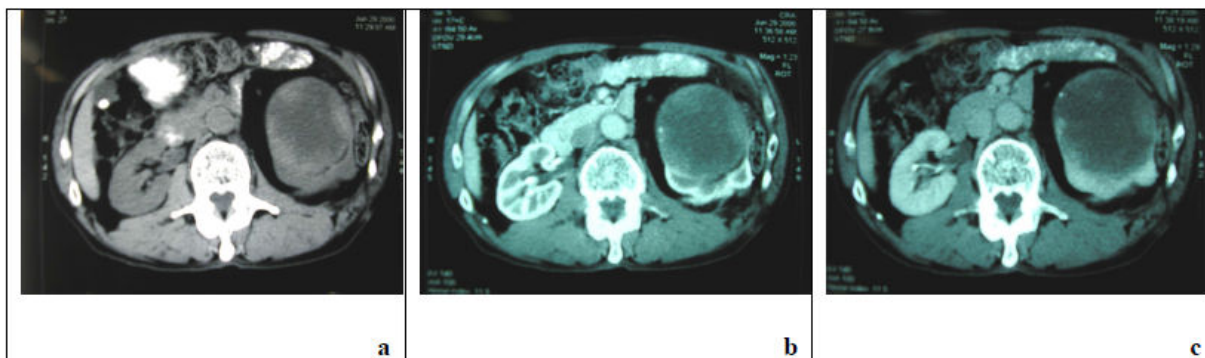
Computed tomography (CT) of the present patient. (a) A heterogeneous low density masse in the left kidney. (b) In the arterial phase, the wall of the masse and peripheral solid component were slightly enhanced. (c) In the late phase, the contrast medium in the wall and peripheral component of the mass was not washed out.
